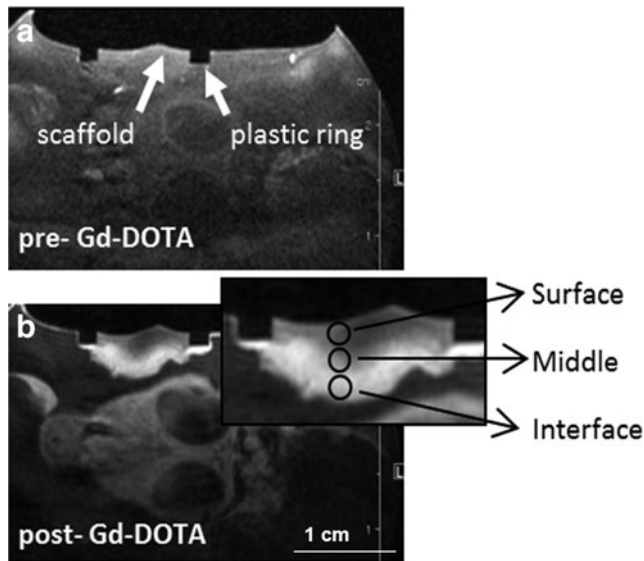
In vivo* T_1 -weighted magnetic resonance images acquired 7 days postimplantation in an axial slice through the scaffold. (a) before (b) 25 min after i.v. injection of Gd-DOTA. Enlarged section: scaffold with regions of interest (circles) at the interface with the CAM, in the middle and on the surface of the scaffold.
